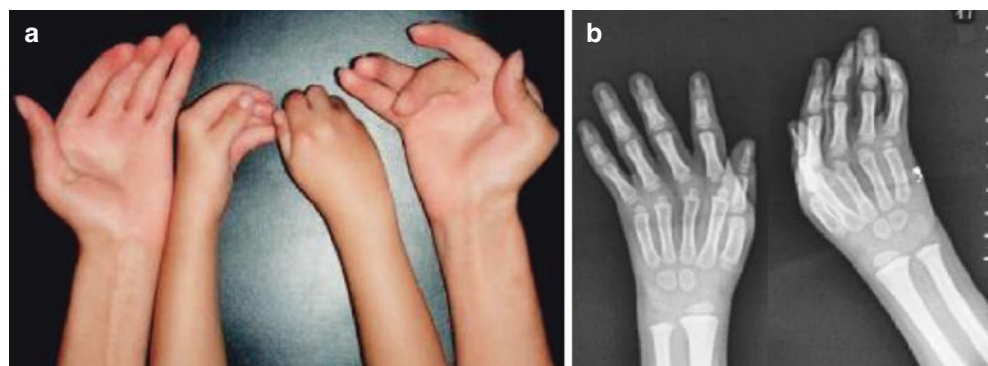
Congenital windblow hand deformity in both hands. (a) The child's two hands are the interior ones, and the two hands of the child's mother are exterior ones. (b) X-ray film of the child's deformed hands
